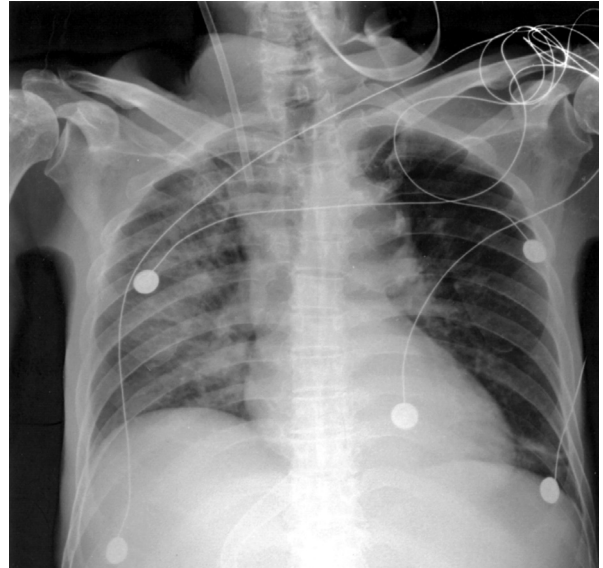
Chest radiograph showing a stent at the portal area and acute lung edema
